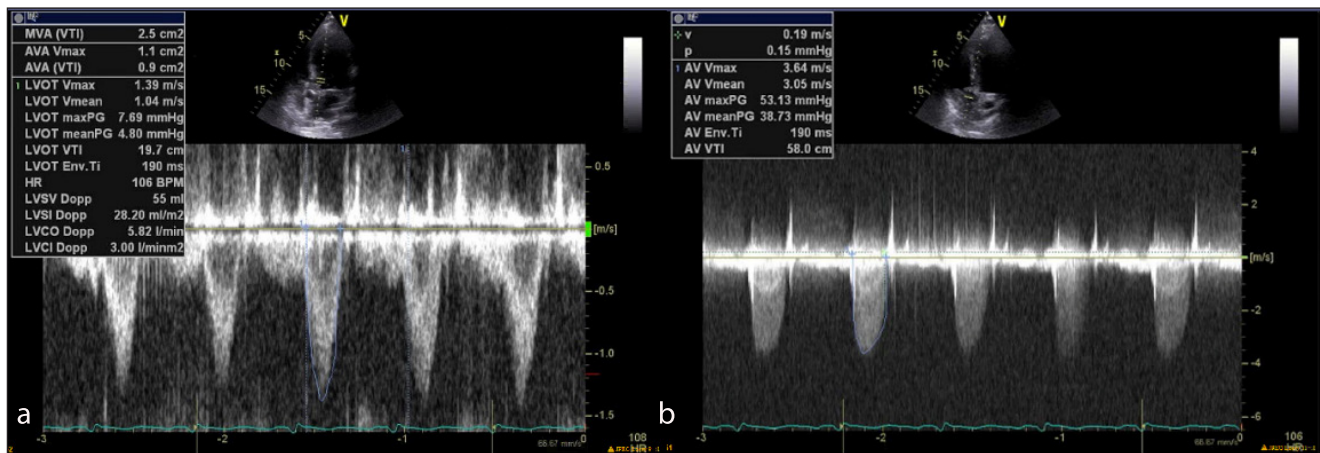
Pulse wave Doppler (2a) and continuous wave Doppler (2b) with evidence of left ventricular outflow obstruction.
